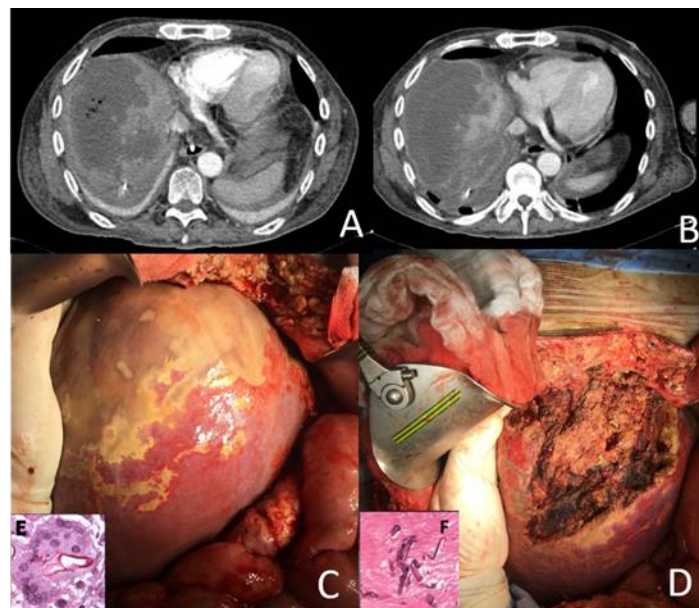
A) CT scan with large zone of hypoperfusion with bubbles of gas in the liver dome. B) CT scan after 5 days of treatment, no gas but progression of lesion. C) Involvement of the liver dome and diaphragm was noticed. D) A non-anatomic hepatectomy was performed.
